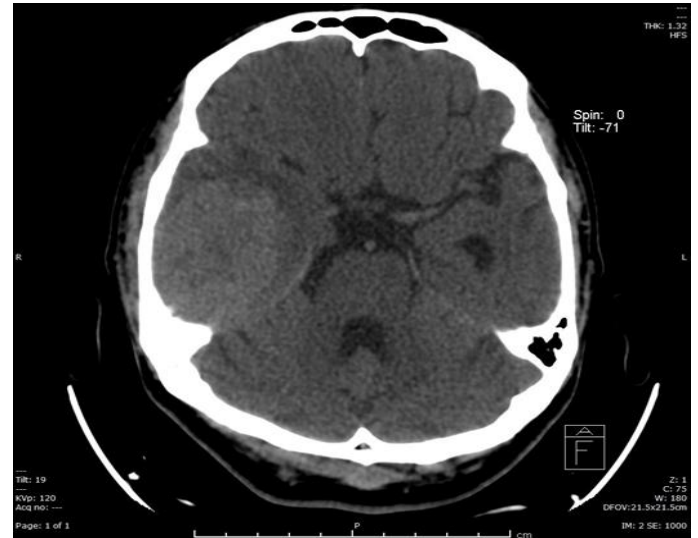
Plain axial CT of brain shows well defined hyperdense extra-axial lesion in the right temporal convexity, with adjacent mass effect.
